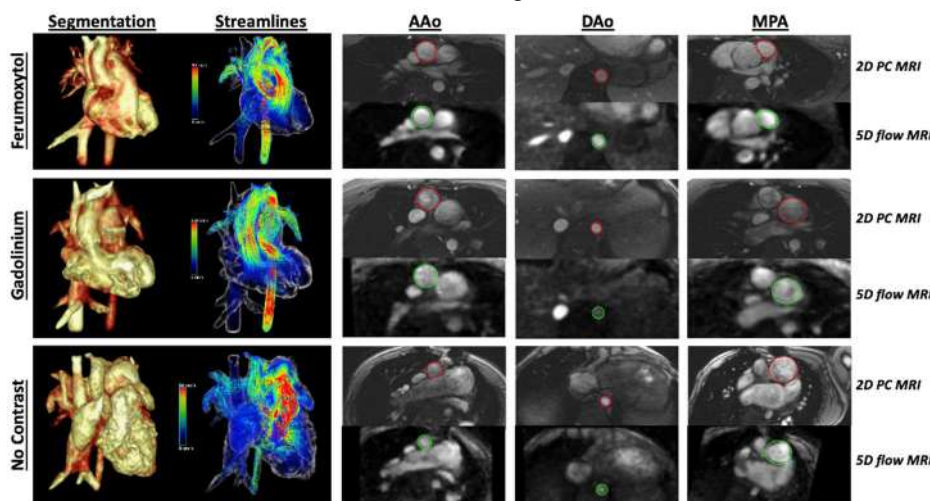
Comparison between three CHD patients acquired with 5D flow MRI. Top to bottom: Ferumoxytol (19y, M, Marfan syndrome), Gadolinium (21y, M, transposition of the great arteries, post-atrial switch), and no contrast (34y, M, tricuspid atresia). Left to right: 3D Segmentation, 3D Streamlines, and 2D contours of AAo, DAo, and MPA.
